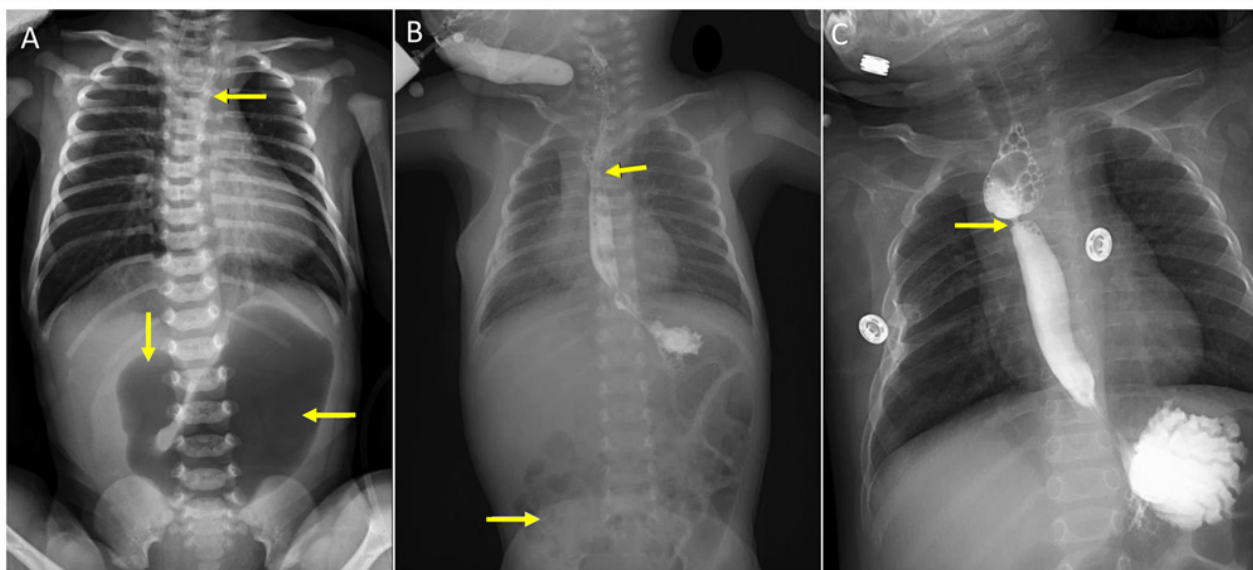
X-ray analysis of patient 2. (A) A preoperative X-ray film showed the combined coiling of the nasogastric tube in the upper esophageal pouch (yellow arrows) and a large gastric bubble with no distal bowel gas (yellow arrows). (B) Upper gastrointestinal imaging confirmed patency of esophageal (yellow arrows) and duodenal anastomosis with distal bowel gas (yellow arrow). (C) Esophageal radiography confirmed esophageal anastomotic stoma stenosis with <2-mm inner diameter at 15 months during the follow-up period (yellow arrow).
